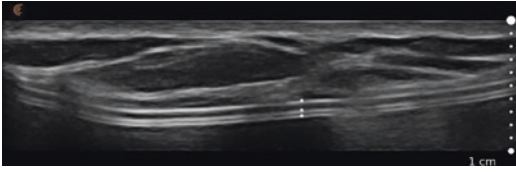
Grayscale ultrasound image of smooth silicone gel breast implant. Top * represents the capsule surrounding the breast implant. The bottom pair of * represent the elastomer shell of the breast implant
